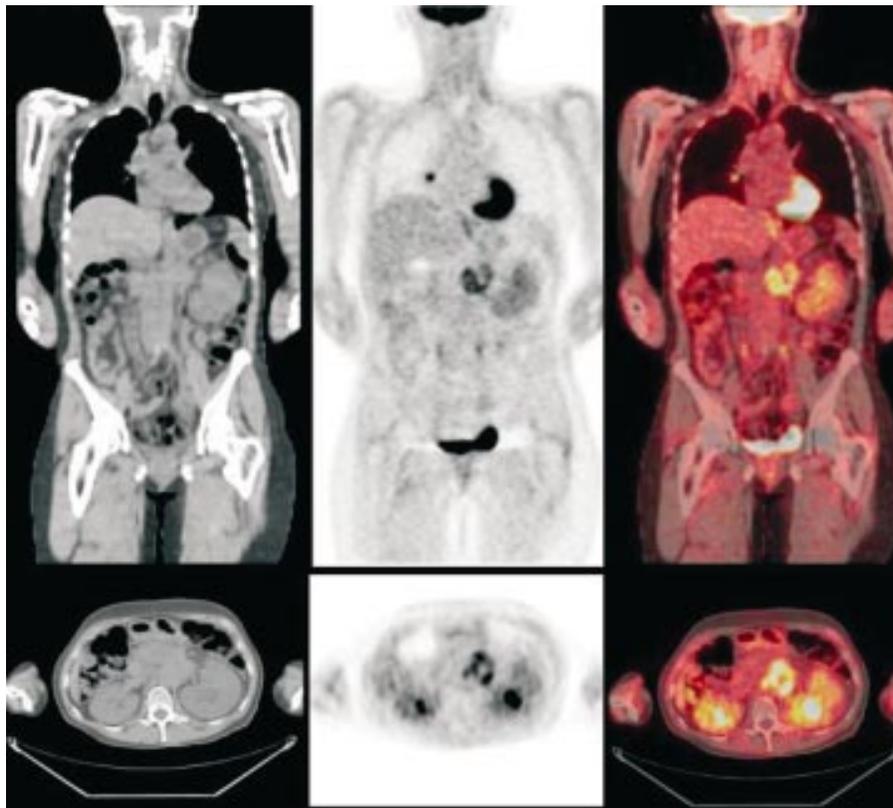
A 43 year old woman with pancreatic cancer presented for evaluation of lung nodules. (Top row) Coronal and (bottom row) transaxial tomographic slices. (Left) CT shows the mass in the abdomen, but is unable to characterise the hilar lymph node. (Centre) FDG PET shows intense activity in the abdominal mass and increased uptake in the hilar lymph node (additional lung abnormalities not shown) compatible with local recurrence and distant metastases. Clinical follow up of lung abnormalities was consistent with metastases. (Right) Fusion of PET and CT localises the abnormalities.
